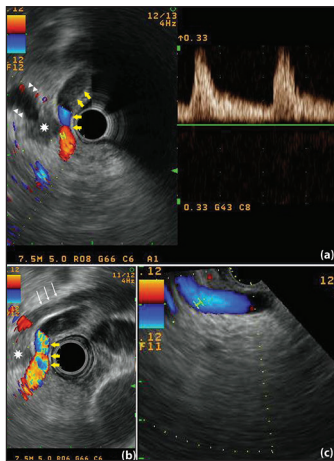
(a and b) Radial EUS image. A 15 mm × 12 mm sized hypoechoic tumor (white star) causing pancreatic ductal dilatation (arrowheads). Portal vein (white arrows), prominent gastroduodenal artery (yellow arrows), and pulse wave Doppler spectrum of the gastroduodenal artery are shown (c) Linear EUS image of the gastroduodenal artery; note the reverse flow toward the hepatic hilum
